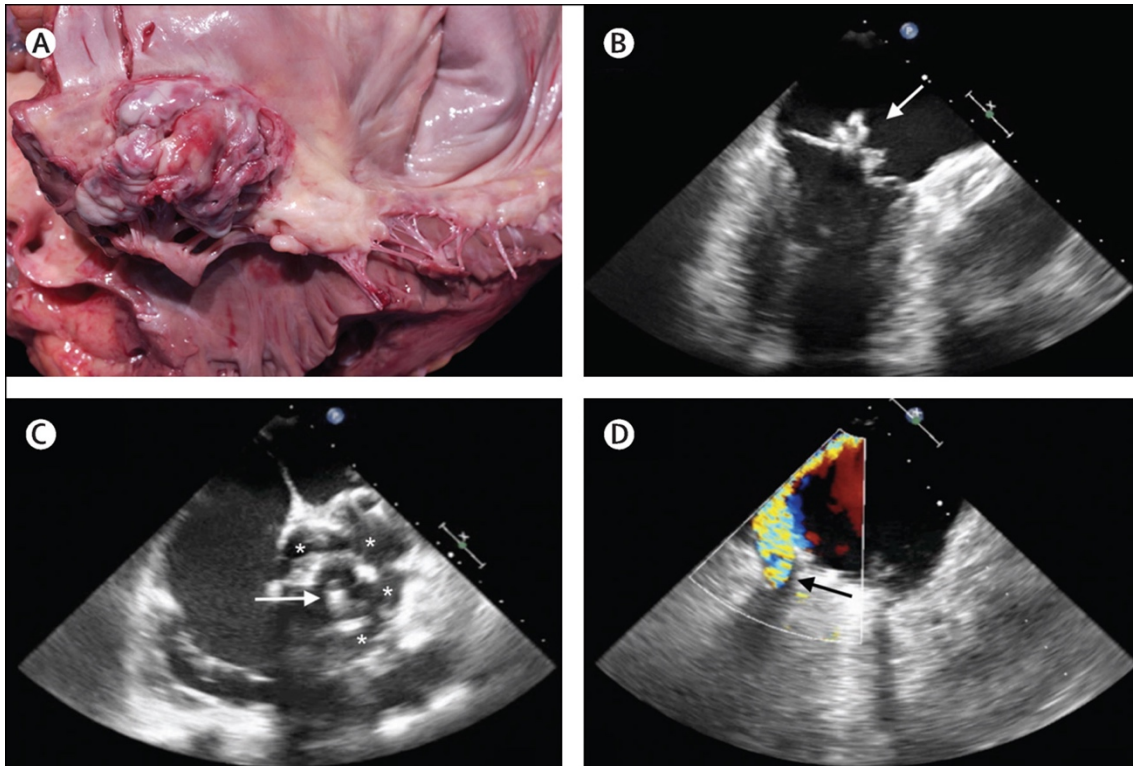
Macroscopic and echocardiographic findings in infective endocarditis.
